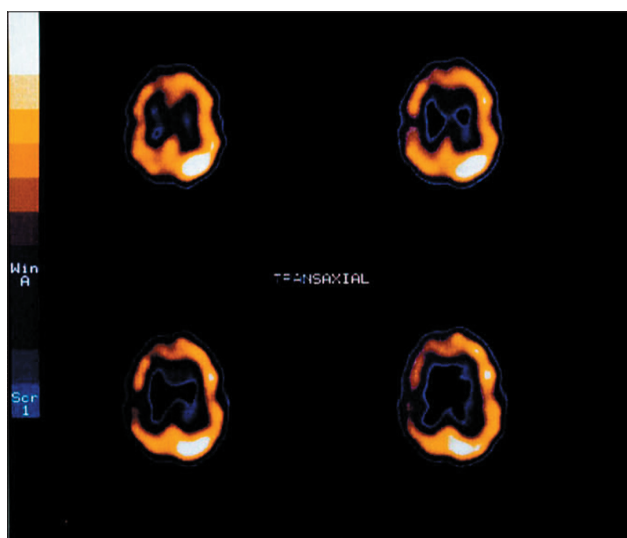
Axial Single Photon Emission Computed Tomography (SPECT) brain scan of a 9-year-old boy who had hemiconvulsion-hemiplegia-epilepsy (HHE) syndrome showing hypoperfusion of the right cerebral hemisphere.
